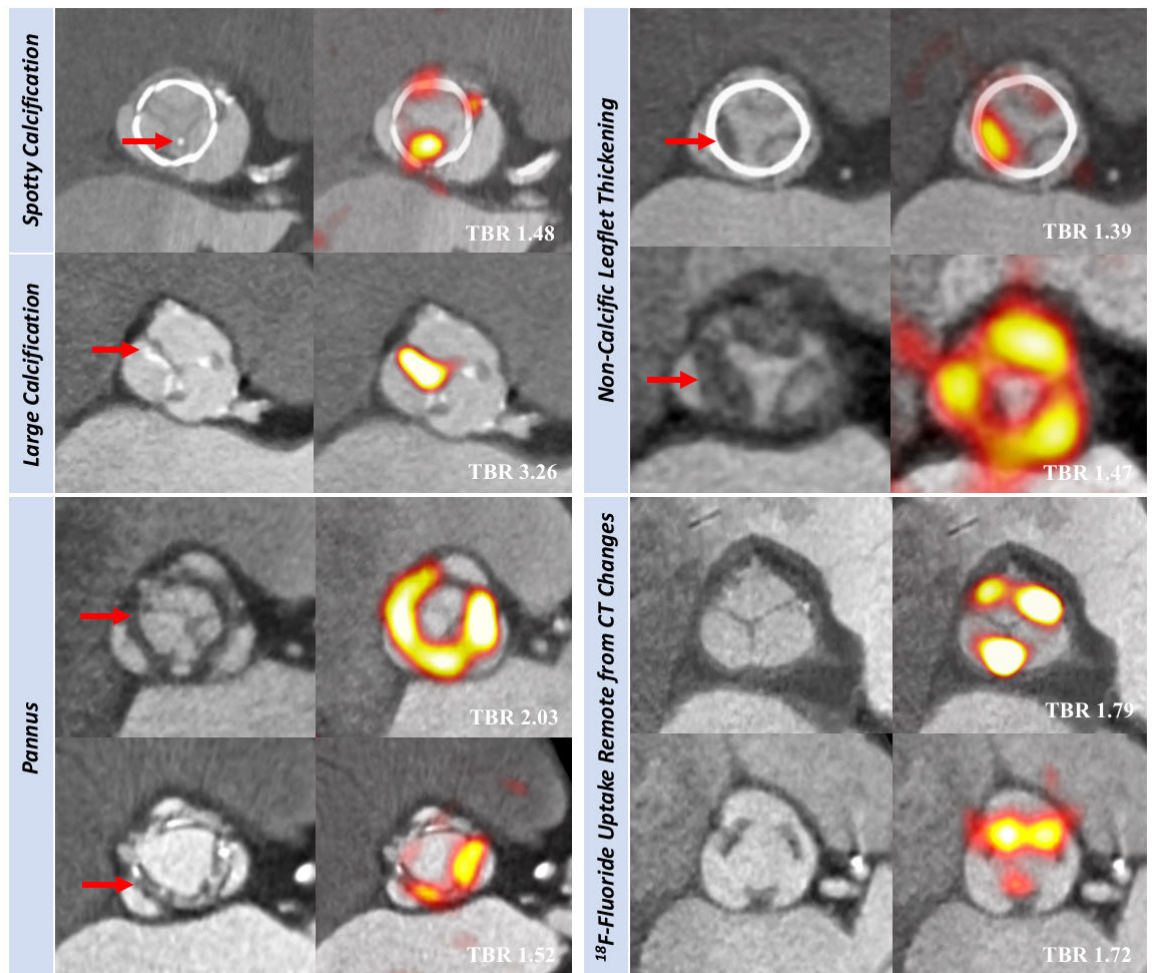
Baseline computed tomography (CT, left) and ^{18}F -fluoride positron emission tomography (PET, right) images from patients with bioprosthetic aortic valves. *En face* CT images of aortic bioprosthetic valves showing spotty calcification and large calcification (top left panel), circumferential pannus (bottom left panel) and non-calcific leaflet thickening (top right panel) (all abnormalities identified by red arrows). Hybrid *en face* PET/CT images in the same patients: increased bioprosthetic
